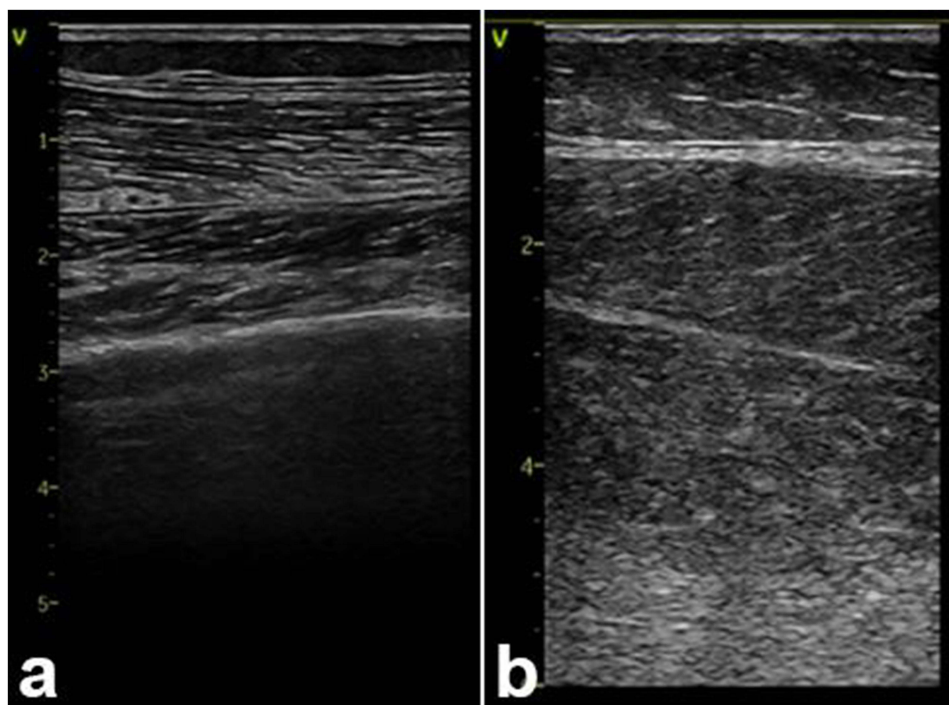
(a) Normal skeletal muscle ultrasound. (b) Skeletal muscle ultrasound of our patient with rhabdomyolysis with disrupted muscle structure.
